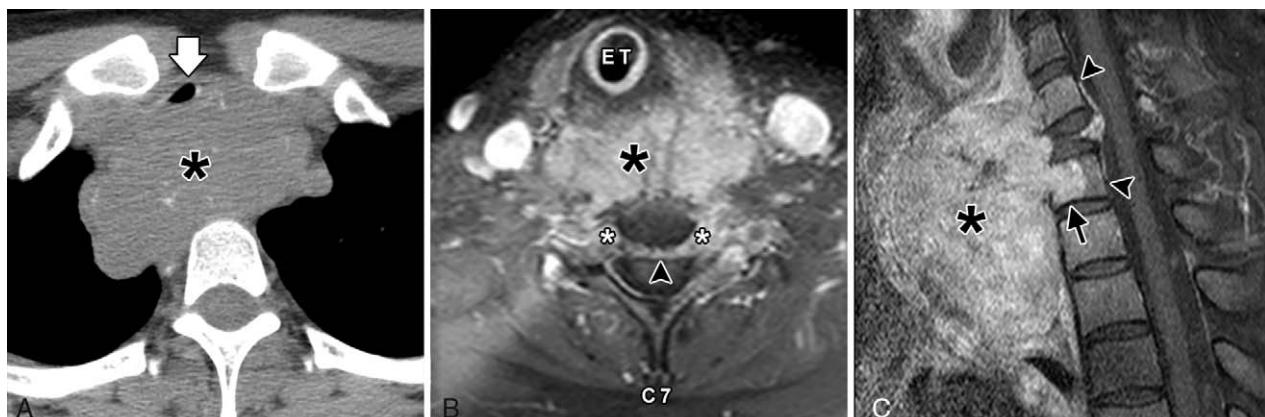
(A) Axial CT image shows a large soft tissue mass (*) compressing the trachea (white arrow). (B) Axial contrast-enhanced MRI with fat suppression at the level of C7 shows a heterogeneously enhancing mass with prevertebral (black *), bilateral neural foraminal (white *), and epidural (black arrowhead) components. An endotracheal tube (ET) is in place. (C) Sagittal contrast-enhanced MRI with fat suppression shows the full craniocaudal epidural extent of disease (black arrowheads), severe compression fracture of C7 with retropulsion into the spinal canal, and secondary involvement of the T1 vertebral body (black arrow) by the soft tissue mass (*). CT indicates computed tomography; MRI, magnetic resonance imaging.
